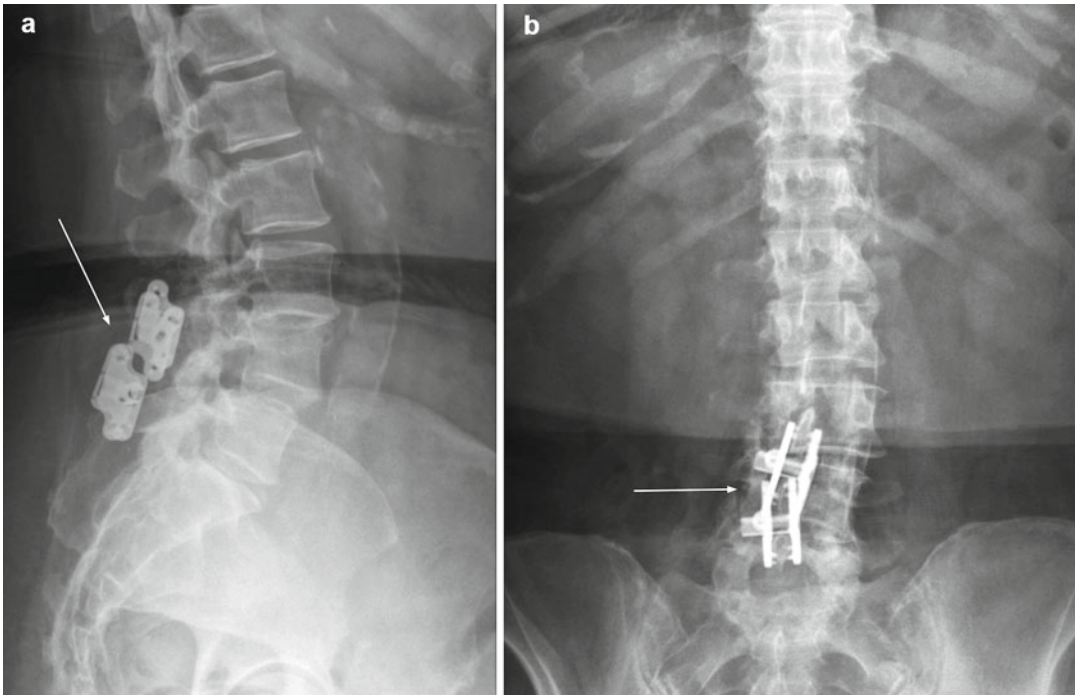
(a) Lateral x-ray depicting interspinous spacer devices placed between L4–5 and L5–S1. (b) AP x-ray of the same devices. Because of the significant spondylolisthesis in this patient, particularly at the L4–5
